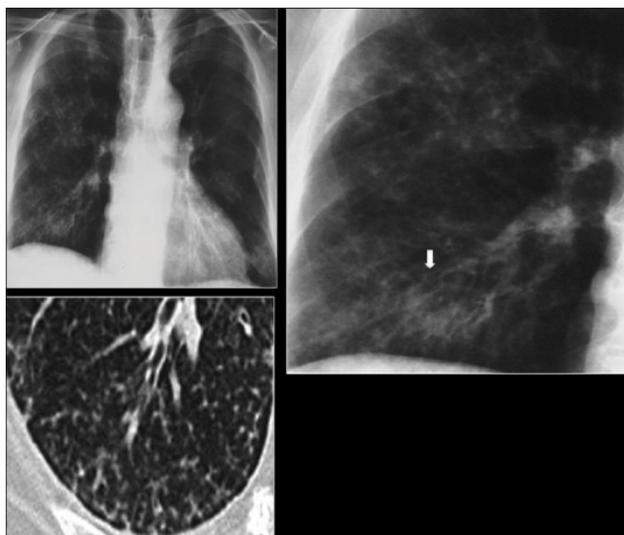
Chest x-ray showing nodule with margins that are indistinct or poorly defined (tree-in-bud sign) of post-primary pulmonary TB.
